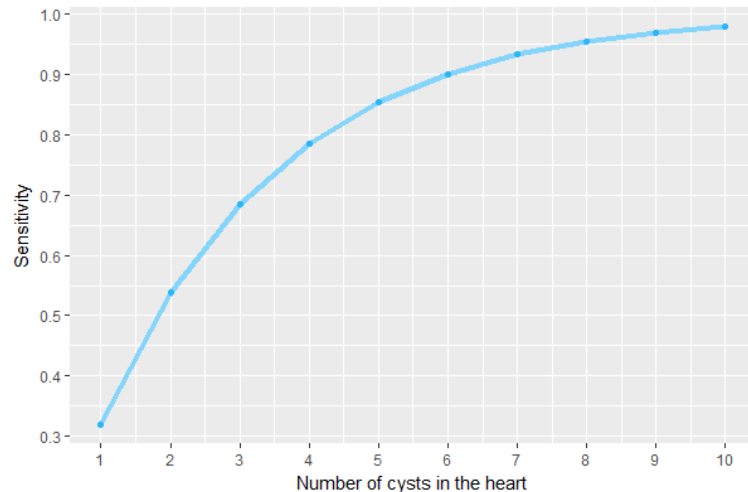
SENSITIVITY OF MEAT INSPECTION
